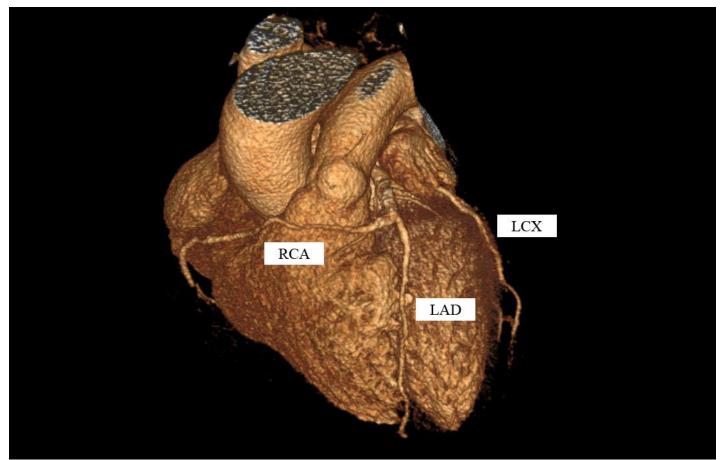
3D reconstruction of CTA coronary shows anomalous RCA, which originates from the mid-portion of LAD and courses anterior to the pulmonary trunk into the right atrioventricular groove.
